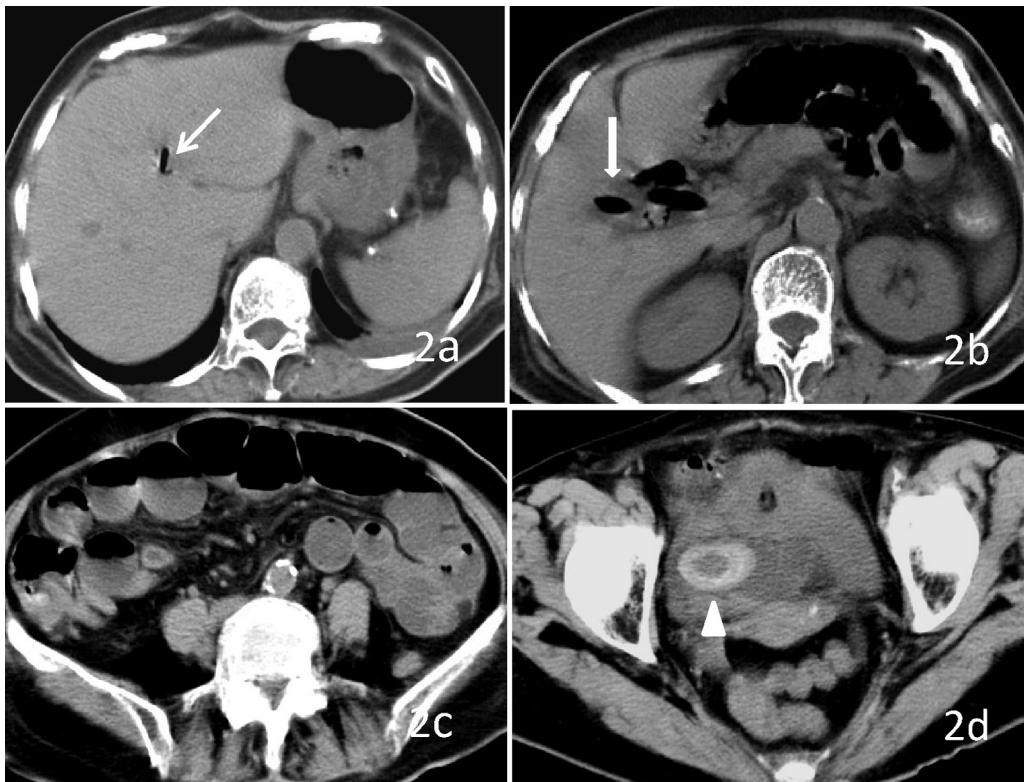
The same case as the Fig. 1. MDCT showed pneumatosis in the bile duct lumen (2a) and gallbladder cavity (2b), low SBO (2c), and ectopic gallstone in ileum cavity (2d). The Rigler's triad was better visualized by MDCT than abdominal X-ray film in identifying ectopic stone and gallbladder abnormality.
